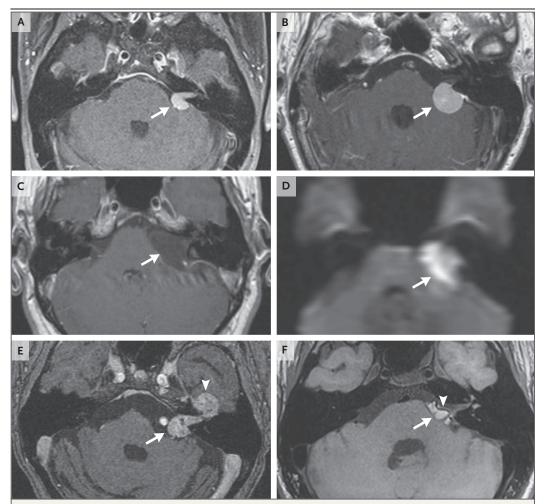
Radiographic Differential Diagnosis of Tumors of the Cerebellopontine Angle.
